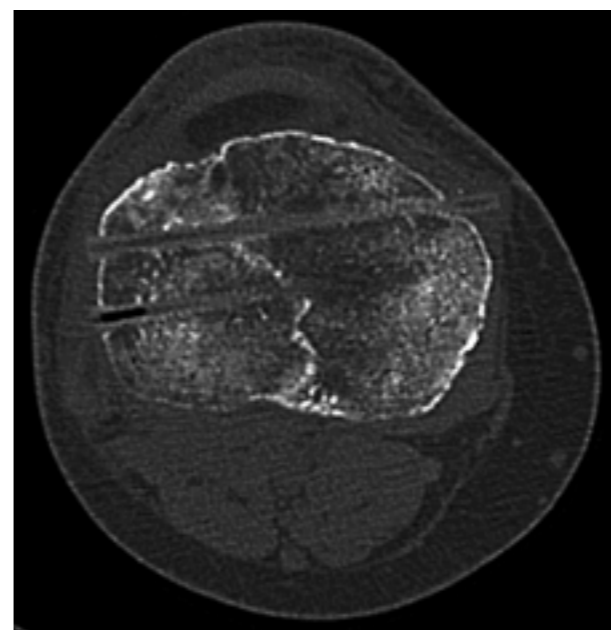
CT scan of the knee joint. Prominent biodegradable screw
